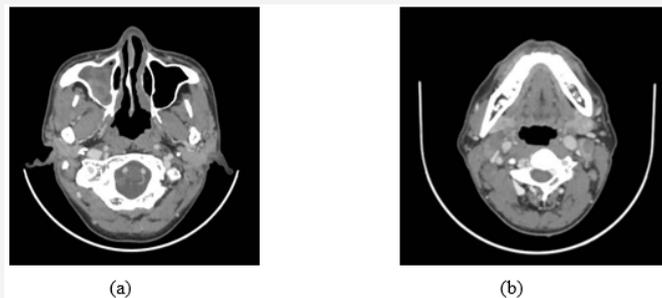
Post-treatment enhanced CT image: (a) The tumor was not seen. (b) Nodals were not changed after treatment.
